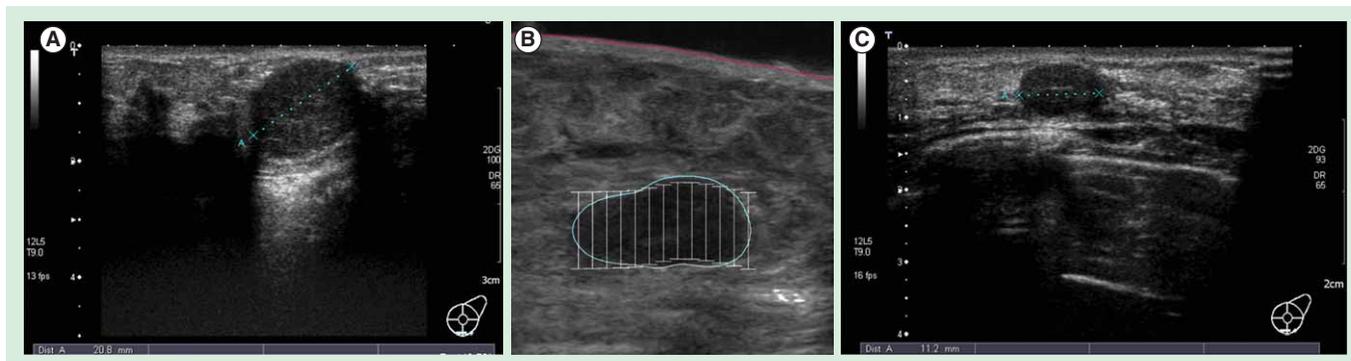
USgFUS of breast fibroadenoma. (A) Ultrasound image acquired on a transversal plane shows a 20-mm fibroadenoma located between the inferior quadrants of the left breast. (B) After manually defining the skin line (red line) and fibroadenoma borders (blue line), the system automatically generates the sonications (white lines) in order to cover the entire volume of the target tissue. (C) The 3-month US follow-up shows a 50% reduction of the fibroadenoma (10 mm of maximum diameter).
